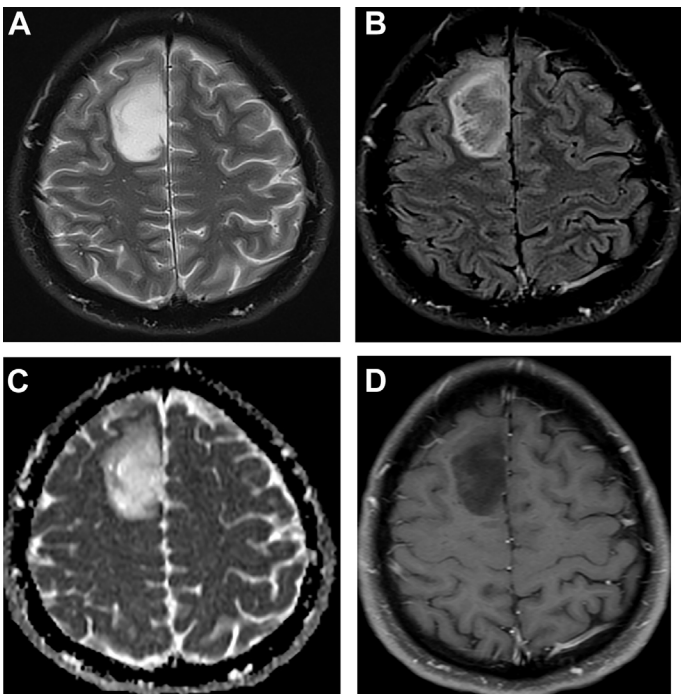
Nondeleted astrocytoma. A 48-year-old man with a right frontal lobe diffuse astrocytoma, *IDH*-mutant, and 1p/19q noncodeleted, showing characteristic imaging features. Axial T2 image (A) shows a well-defined hyperintense mass in the right frontal lobe without much perilesional edema. Axial FLAIR image (B) shows hypointensity to isointensity in the central portion of the mass with surrounding hyperintensity. This is called T2-FLAIR mismatch sign. Mass shows high ADC and no enhancement on axial ADC (C) and postcontrast T1-weighted image (D).
